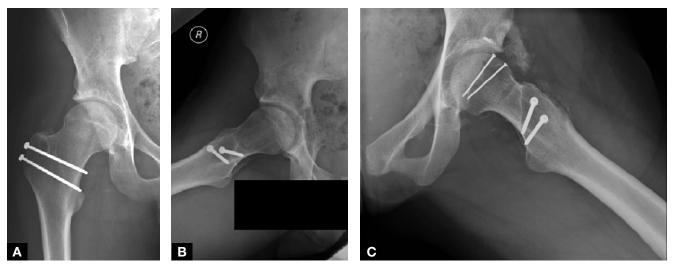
Case 1: Anteroposterior (A) and frog-leg lateral (B) radiographs of right hip at final follow-up show no significant hip arthrosis; also visible is mild heterotopic ossification at greater and lesser trochanter. (C) Case 2: Frog-leg lateral radiograph of left hip at final follow-up shows no significant hip arthrosis, but moderate heterotopic ossification is present.
